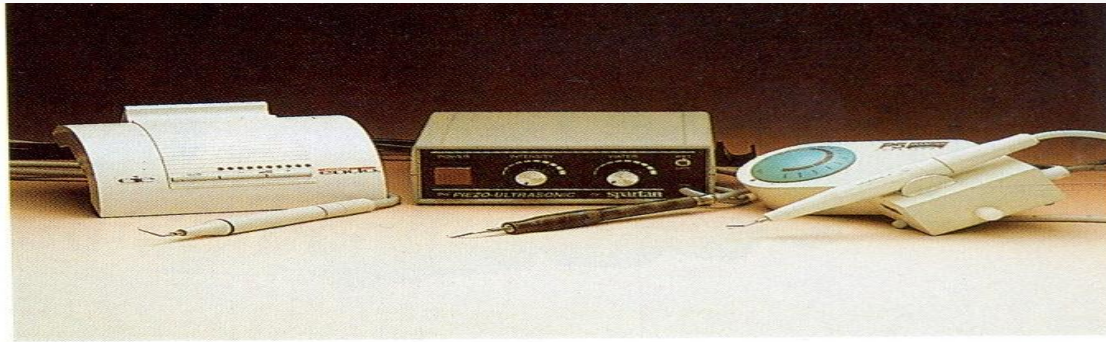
Ultrasonic units. *Left*, EMS Miniendo (Analytic Endo). *Center*, Spartan (Spartan/Obtura). *Right*, P-5 (Satelec).
